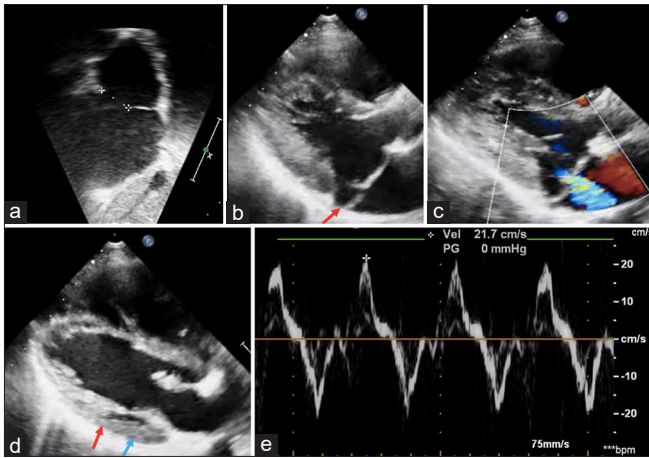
Transthoracic echocardiography of case 2. (a) Subcostal long-axis view showing the ostium secundum atrial septal defect measuring 19 mm. (b) The parastral long-axis view shows bileaflet mitral valve prolapse and the systolic displacement of the lateral hinge point of the posterior mitral leaflet (Red arrow). (c) The parasternal long-axis view with color Doppler shows moderate mitral regurgitation. (d) Parasternal long-axis view showing thickening of the posterior wall near annulus (blue arrow) and thinning of the mid posterior wall due to systolic curling of the left ventricular base (red arrow). (e) Tissue Doppler of the basal left ventricular myocardium showing a midsystolic peak of 21.7 cm/s (Pickelhaube sign)
